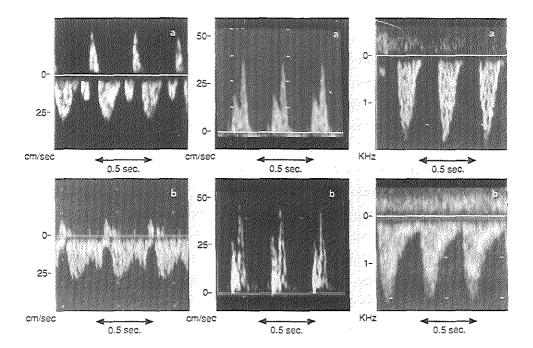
Doppler flow velocity waveform tracings from the inferior vena cava (IVC), tricuspid valve (TV) and umbilical artery (UA) at 11 weeks (upper panel;a) and 16 weeks of gestation (lower panel;b).
